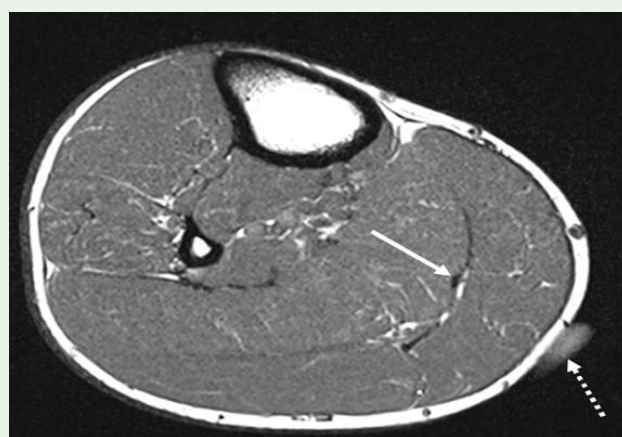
43-year-old professional boxer in training for a fight, presenting with recurrent lateral right calf tightness preventing him from running, with a history of medial calf strains. a Axial PD right calf MRI several months prior to calf adhesiolysis showed thickening of the plantaris tendon (arrow) within the medial calf aponeuroses, due to peritendon scar tissue. Note the oil bead (dotted arrow) adjacent to the thickened plantaris, indicating symptomatic medial calf at the time of MRI, which was reported as 'normal'.
